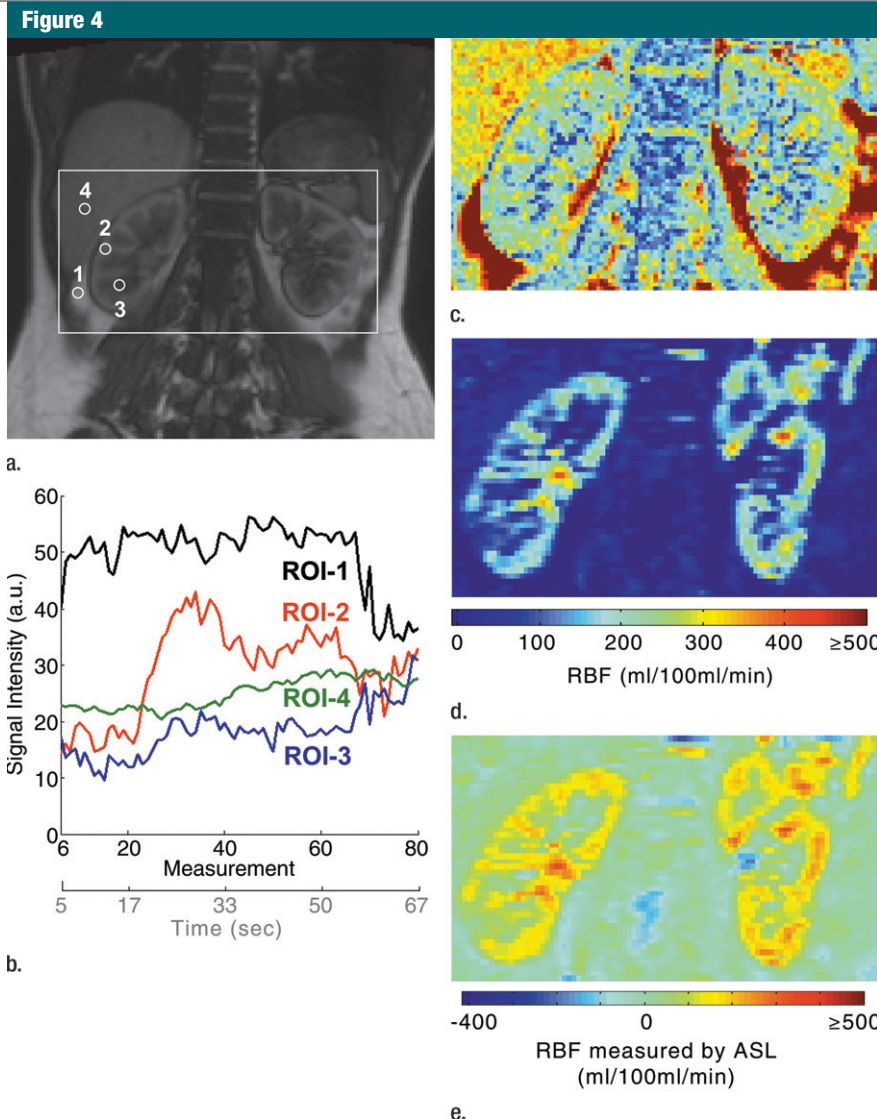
shows typical results of ASL and DCE MR imaging performed in one healthy volunteer.
